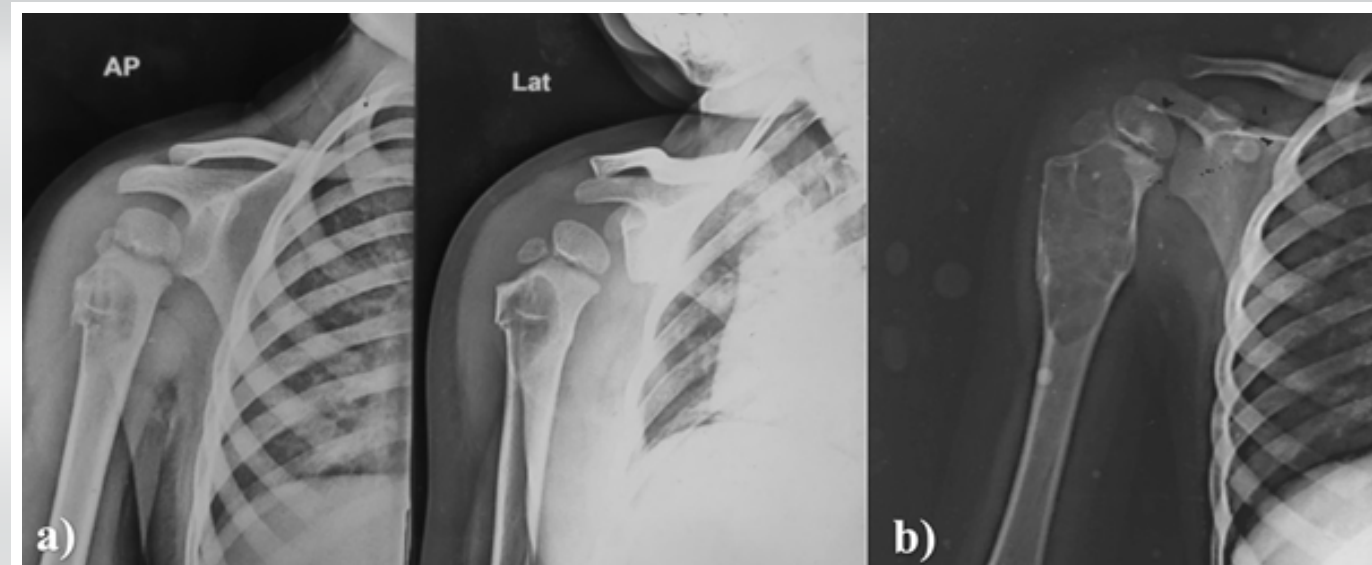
Radiograph of 2 year old male aneurysmal bone cyst of the proximal humerus a) showing pathological fracture b) showing no healing of the cyst with fracture healing.
